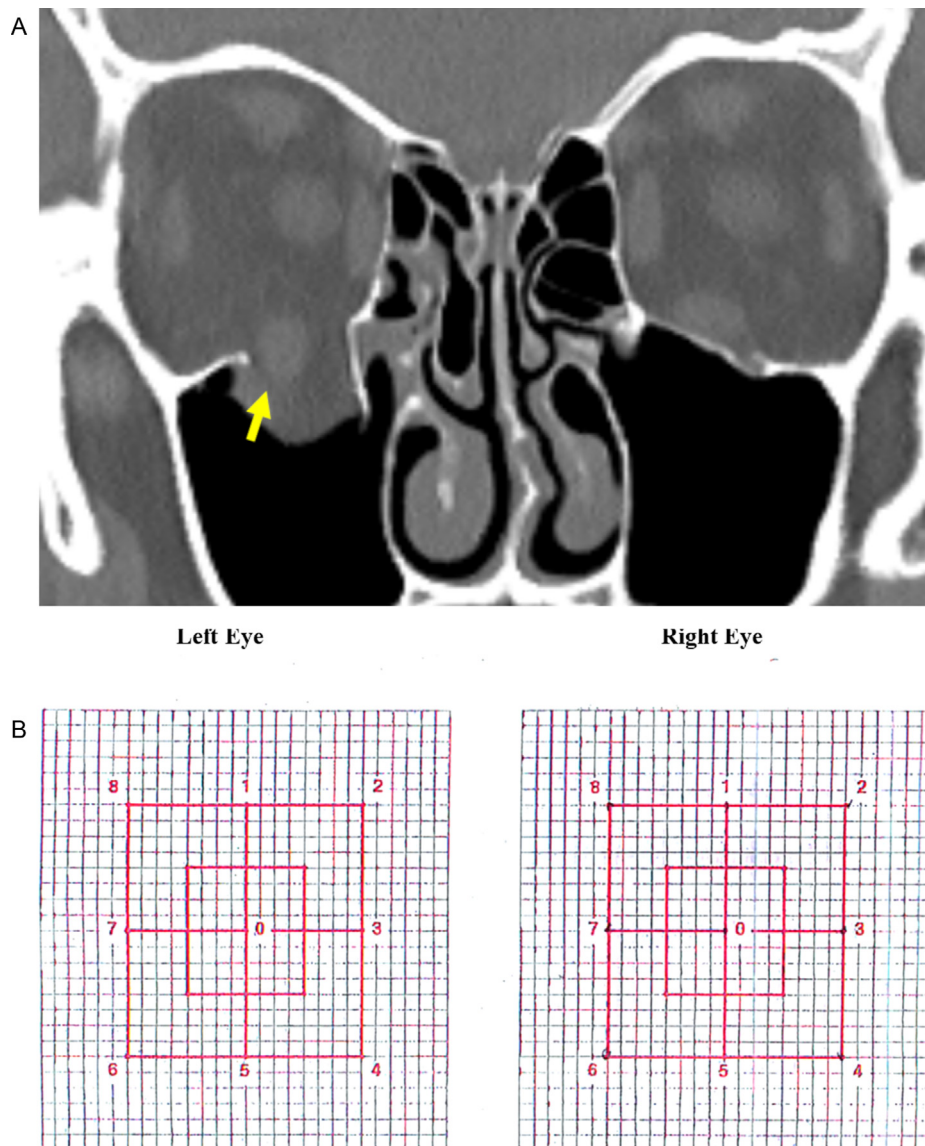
Case 2: Initial post-trauma coronal CT scan images (A) showing a 2.5 cm² left displaced blow-out fracture, with a significant herniation of orbital tissues with most of the inferior rectus muscle within the maxillary sinus. The identical 10-day and the 1-year (B) posttrauma Hess-Weiss coordimetry showing normal binocular eye motility.
